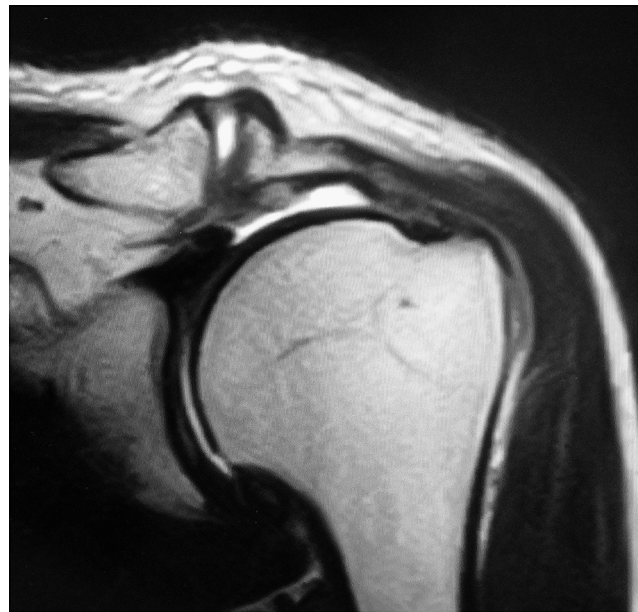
Magnetic resonance imaging finding prior to surgery.
